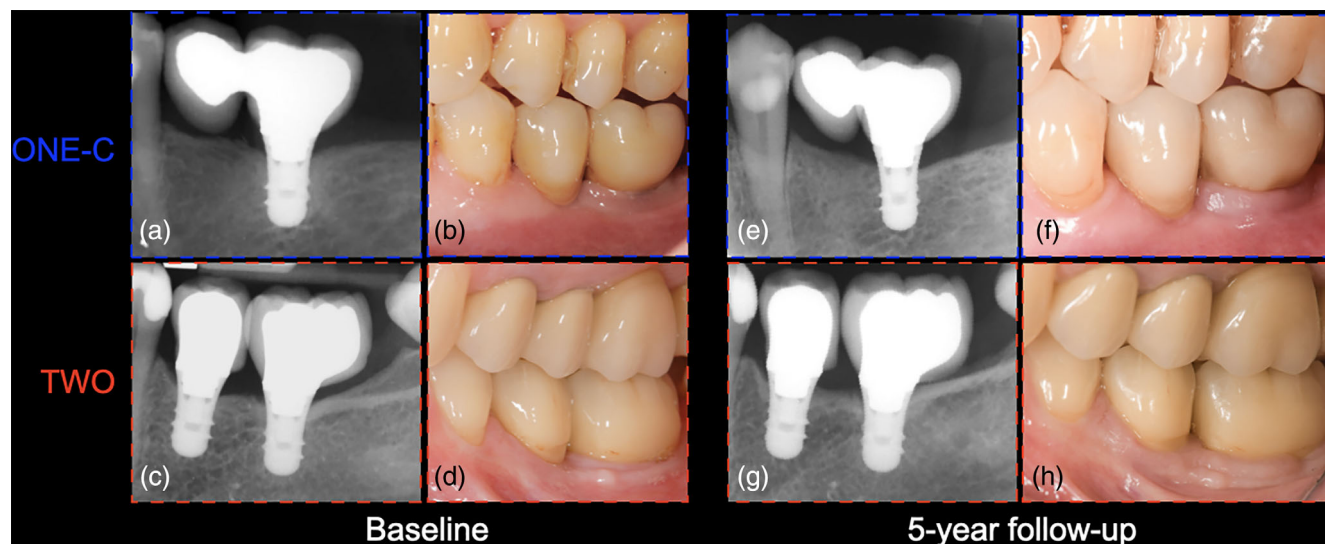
Representative cases of each treatment modality. Periapical radiographs (a,c) and clinical situation (b,d) at baseline (crown delivery). Periapical radiographs (e,g) and clinical situation (f,h) at 5 years follow-up
